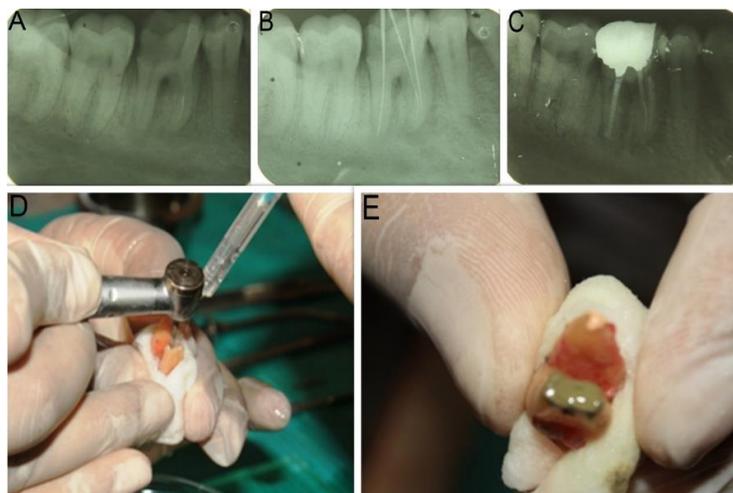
(A) Preoperative Radiograph (B) Working Length Radiograph (C) Post obturation Radiograph (D) Root End Preparation (E) MTA root end filling
